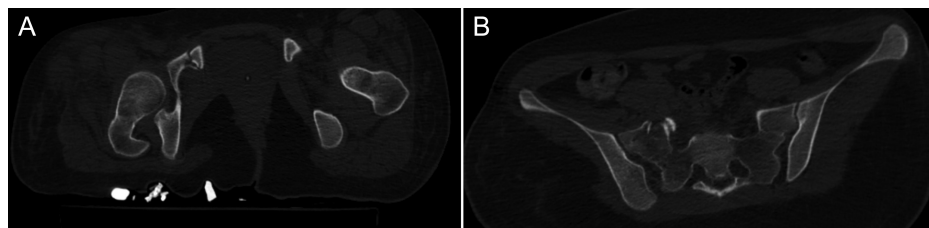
Image of the pelvis of a 23-year-old woman. Axial CT shows the fracture of right superior pubic ramus (A) and sacral fracture (B). CT, computed tomography.
